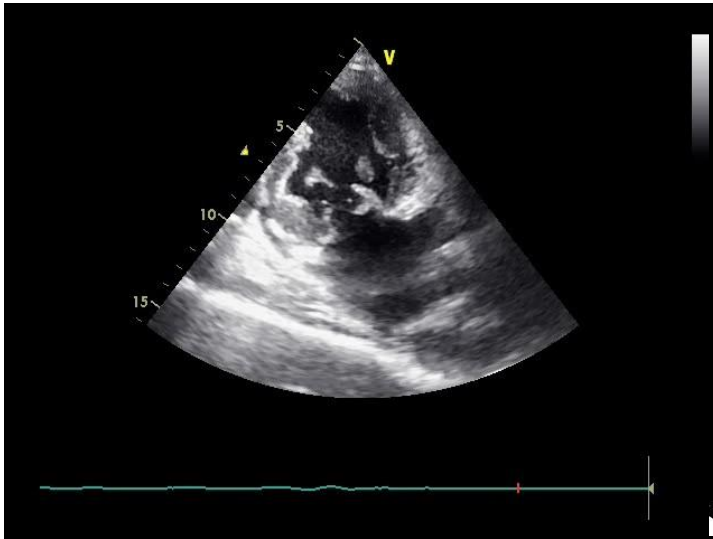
Transthoracic echocardiography (apical two chamber view) showing mitral leaflet vegetations.
